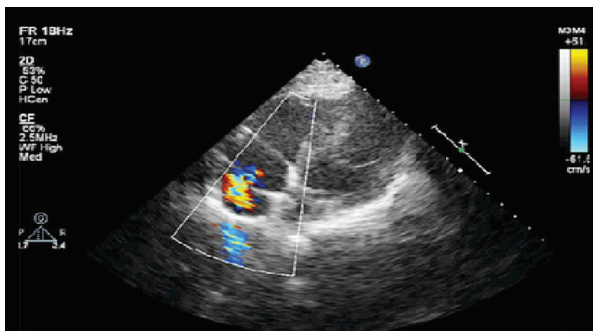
Color Doppler image of turbulence seen in the fibromuscular membrane.
